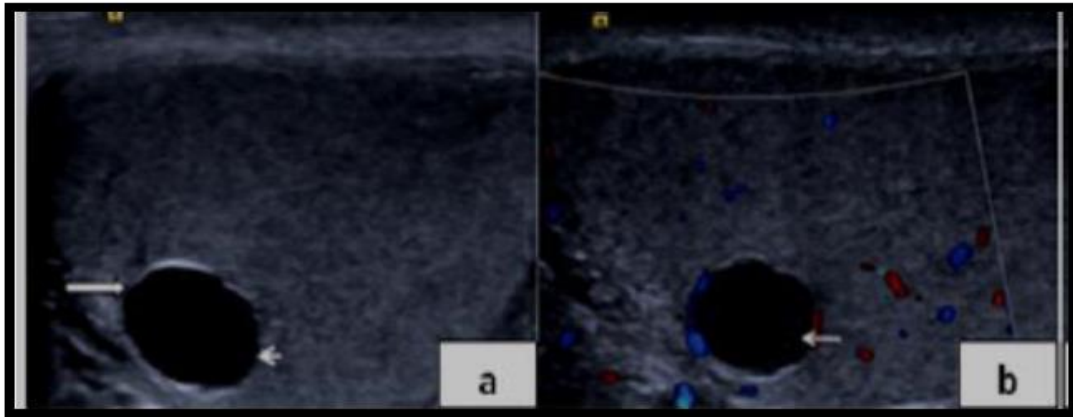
shows the Cyst with debris. (a) A 6-mm anechoic lesion (long arrow) is noted in the testicle with a thin clear demonstrated. A “fluid-debris” level is noted (short arrow). (b) No internal color Doppler signal is demonstrated within the debris present in the lower aspect of the cyst (arrow) (Dogra et al, 2001).
